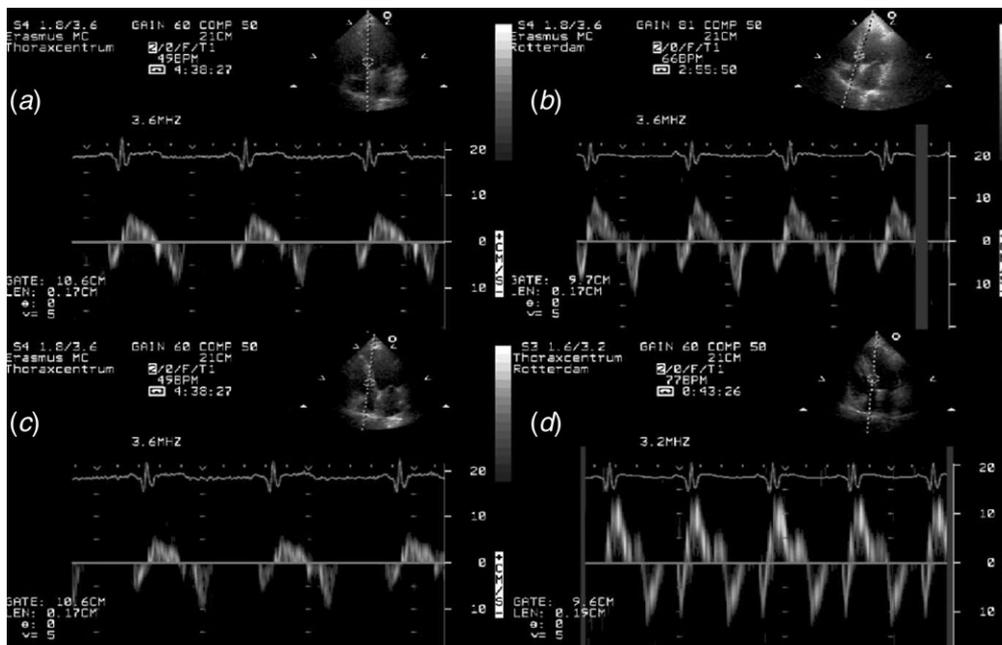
A significant increase of peak systolic velocity measured by TDI is shown at baseline (upper part) and at 1-year follow-up (lower part) both at rest (A and C) and after a low-dose dobutamine stress echocardiography (B and D).
